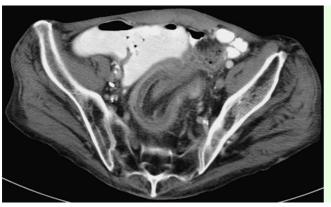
Abdominopelvic CT image of sigmoid intussusception.
